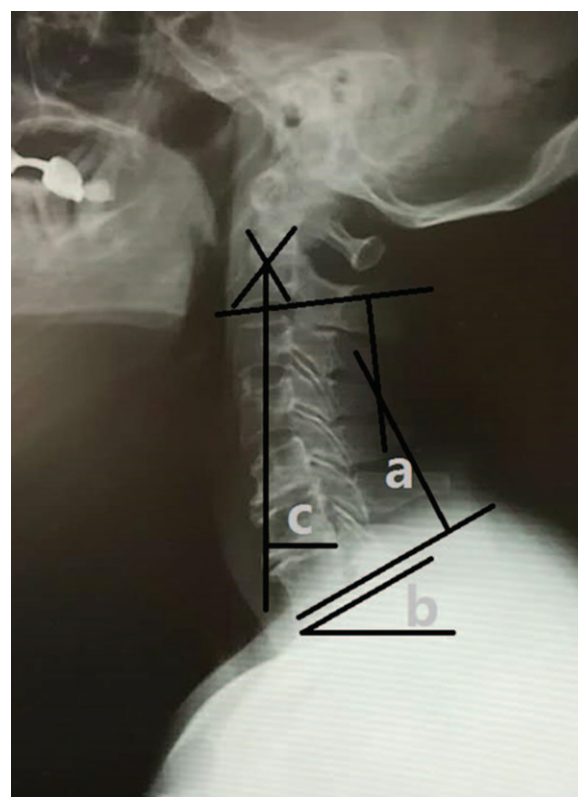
Cervical lateral, extension and flexion radiographs. (A) C2 to 7 Cobb angle (defined as the angle formed by the inferior endplates of C2 and C7 in lateral radiographs). (B) T1 slope (the angle between a horizontal line and the superior endplate of T1 on lateral radiograph). (C) C2 to 7 SVA (distance from the posterosuperior corner of C7 and the vertical line from the center of the C2 body). SVA=sagittal vertical axis.
